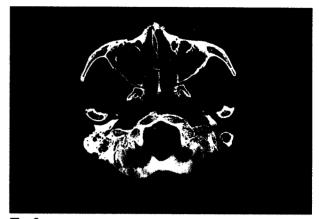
Preoperative CT shows nasal bone fracture with maxilla fracture
